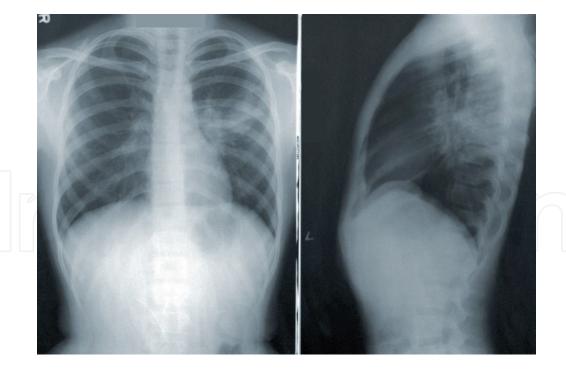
Anterior–posterior and lateral chest radiograph of bilateral hilar lymphadenopathy (image courtesy of H. Bruce Dull, MD).
